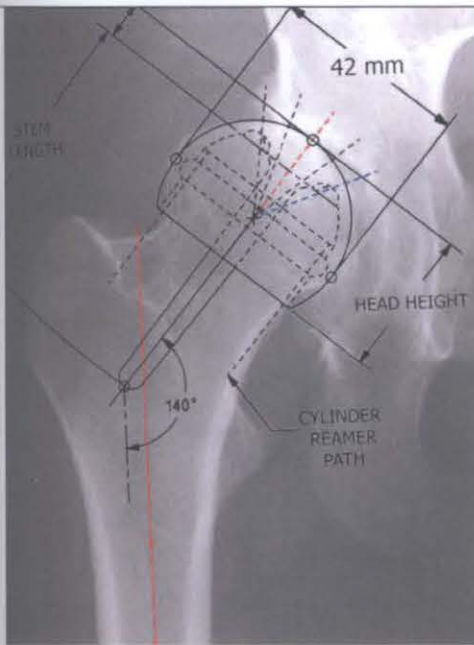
The template, when placed on the anteroposterior radiograph at 140°, allows visualization of the entry point (red dotted line) of the pin with respect to the location of the ligamentum teres (blue dotted line).
